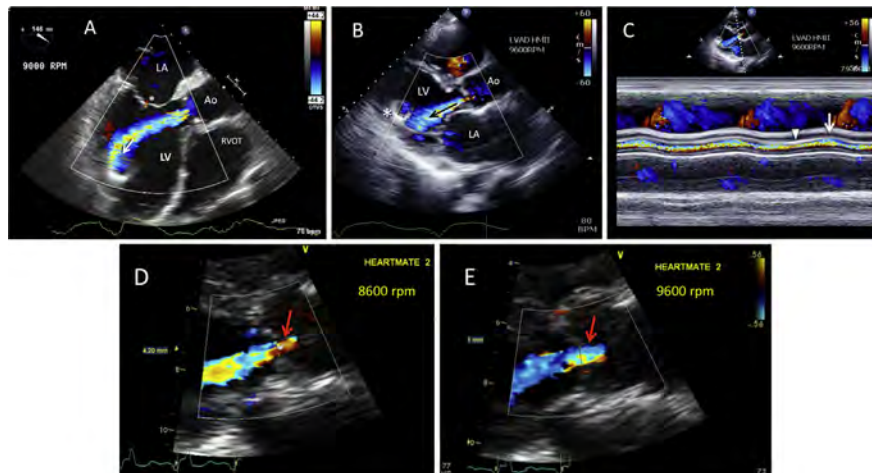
Assessment of AR. (A) TEE shows at least moderate—and possibly severe—continuous AR during LVAD support. The AR VC is clearly >3 mm, and the jet width/LVOT width is clearly $>46\%$. Color-flow Doppler reveals inflow-cannula systolic entrainment of the AR jet (arrow). A closed MV and trace MR (*) are indicative of marked systolic AR. RVOT, right ventricular outflow tract. See also Video 8. (B, C) During LVAD support, at least moderate continuous AR (arrow) is observed in the transthoracic parasternal long-axis view with color Doppler (B) and color M-mode imaging (C); the inflow cannula is denoted by an asterisk. In view C, note the variance in the early systolic (arrowhead) versus late systolic (arrow) AR VC width, as shown by M-mode. This finding is not consistent among different patients; it is likely influenced by several variables and by the fact that the AV cusps can exhibit augmented systolic opening, despite AR, at speeds close to (but below) the AV “opening speed.” See also Video 9. (D–E) The AR VC width may increase at higher pump speeds in the same patient, as seen here. This may partially be due to an increased systemic arterial pressure at higher pump speeds, which presumably increases the AR volume. At both speeds, the VC is >3 mm, indicating at least moderate—and possibly severe—AR. The VC width is 4.2 mm at 8600 rpm in view D and is 5.7 cm at 9600 rpm in view E (HM-II LVAD). (F) “Continuous” holosystolic and holodiastolic AR, as detected by continuous-wave Doppler (TTE apical 5-chamber view). (G) Continuous-wave Doppler (TTE apical 5-chamber view) reveals nearly continuous AR, which significantly extends into the electrical and mechanical systolic period with a brief period of AV systolic forward flow (arrows). (H) Color M-mode shows minimal AV opening, with a brief duration of low-velocity systolic forward flow (arrows). (I) TTE parasternal long-axis view of an AR jet on color-flow Doppler imaging (arrow). (J) The AV opens widely, with forward flow that interrupts AR. However, the AR period extends into the electrical and mechanical systolic period (arrows) during HVAD pumping at 2600 rpm.
